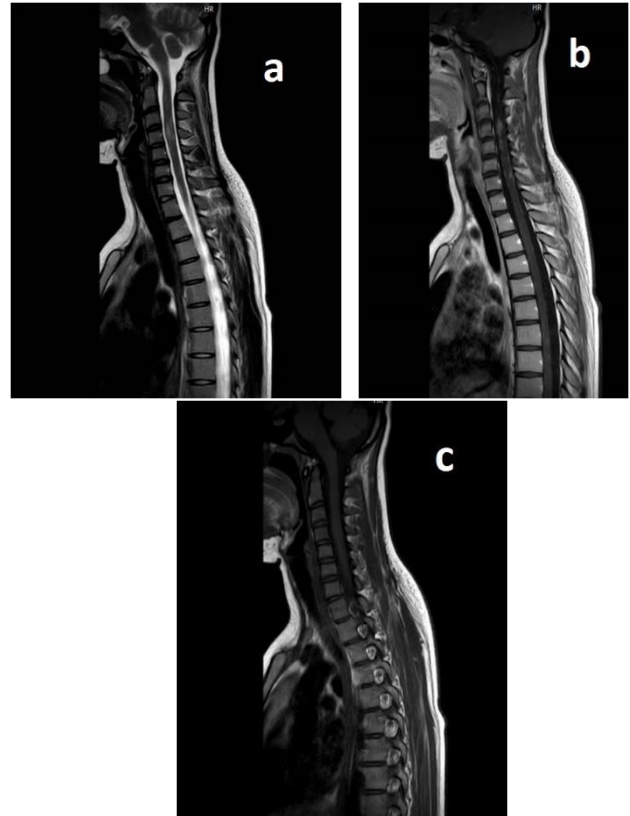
Cervical sagittal MRI sequences of T2A (a), post-contrast (b) and pre-contrast (c). T2A images showed a mild expansile lesion with contrast enhancement in the patient's cervical spinal cord.
